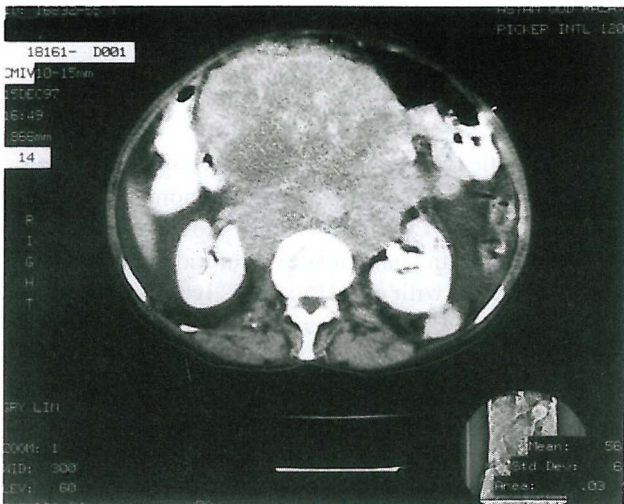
Abdominal CT scan showing ascites and a large para-aortic heterogeneous mass with encasement of the aorta and right renal vein.
